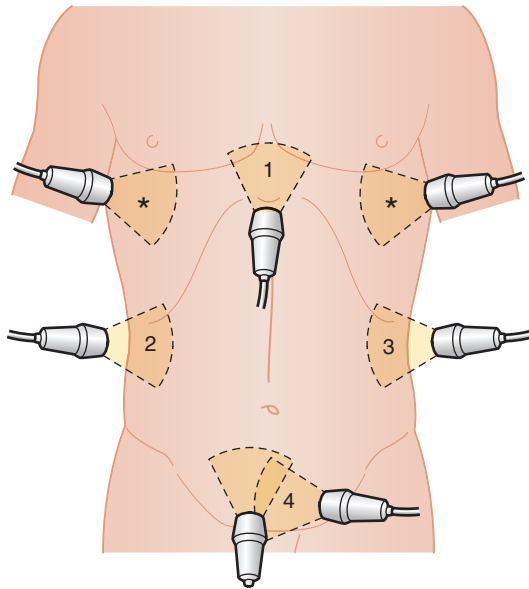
■ The extended focused assessment for the sonographic evaluation of the trauma patient, or E-FAST, examination using four standard viewing ports (numbered): right upper quadrant, left upper quadrant, pelvis, subxiphoid, and the extended views of the left and right hemithoraces (*asterisks*). (From Körner M, Krötz MM, Degenhart C, et al: Current role of emergency US in patients with major trauma. *Radiographics* 28:225–242, 2008.)
